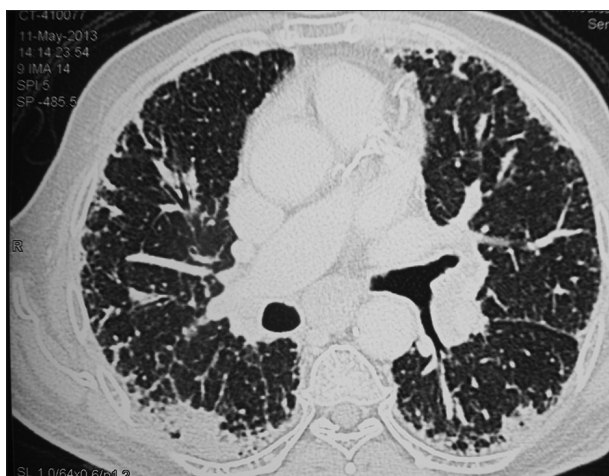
Post treatment computed tomography scan chest, coronal view
